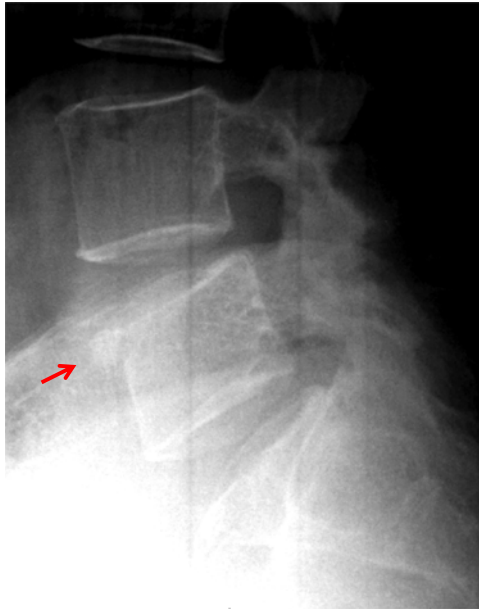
Lateral radiograph of the lumbar spine demonstrating the fracture at the anterior–superior aspect of the L5 vertebra, indicated by the arrow.
